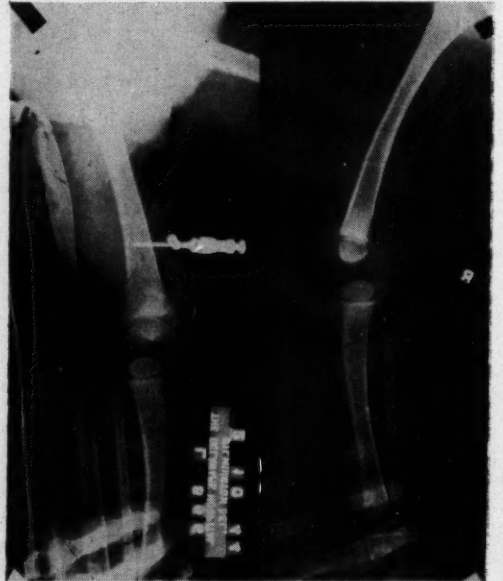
Roentgenograms of anterior and lateral views of (case 12) child 14 months showing needle in the bone marrow space. Note puncture areas in other bones.
